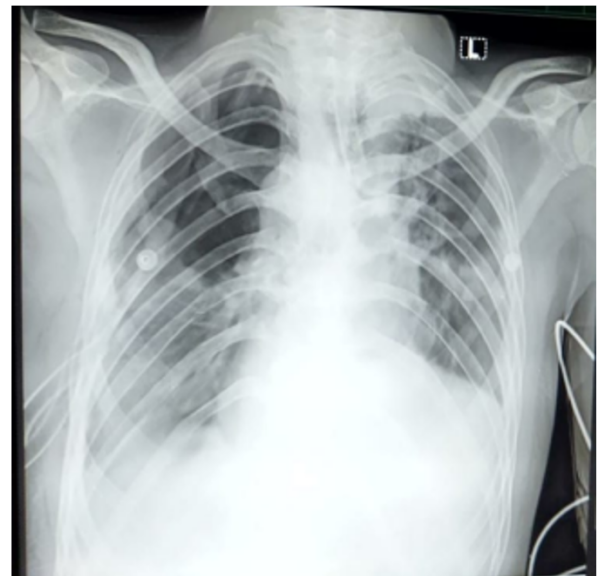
Preoperative chest x-ray of the patient
